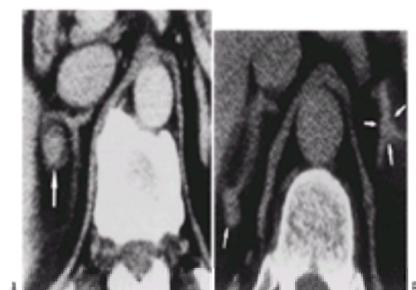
Computed tomographic scans of two patients with clinical features of primary aldosteronism. A: A 1.5-cm solitary adenoma (arrow) in the right adrenal. The diagnosis of aldosteronoma was confirmed with relief of the syndrome by resection of the gland. B: Several 9-mm nodules (arrows) in both adrenal glands, which are hyperplastic. The patient's hypokalemia and hypertension were controlled medically. (Reprinted from Radin DR, Manoogian C, Nadler JL. Diagnosis of primary hyperaldosteronism: importance of correlating CT findings with endocrinologic studies. *AJR Am J Roentgenol* 1992;158:553–557, with permission.)
